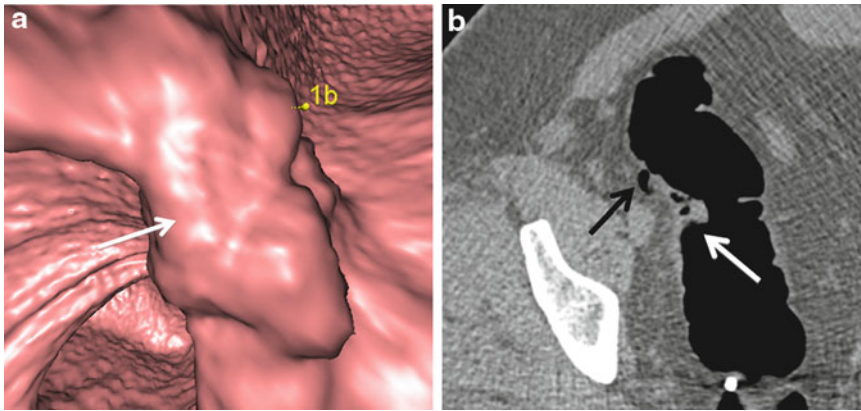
Deep biopsy or polypectomy is a risk factor for perforation during CT colonography. (a) 3D endoluminal view of the sigmoid colon demonstrates a large, irregular, nearly obstructing mass lesion. This lesion had undergone biopsy earlier in the day, and the scan was ordered to clear the proximal colon of synchronous lesions. (b) Corresponding 2D axial supine image
